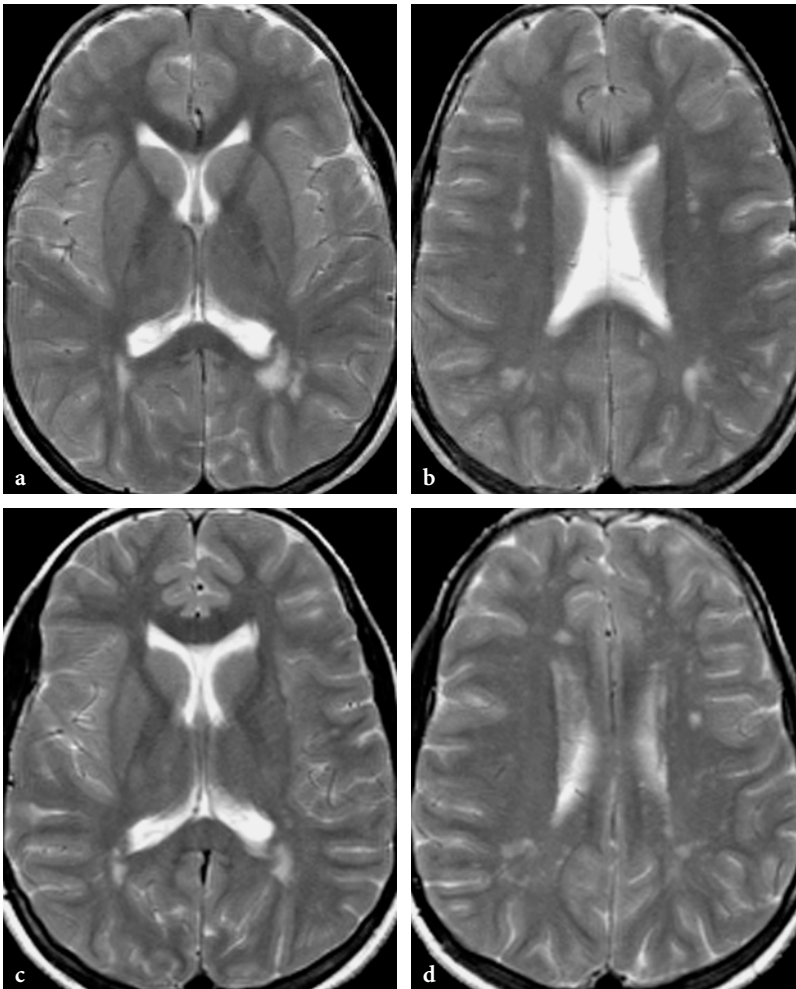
MR imaging findings in galactosemia in twin sisters (both images at the age of 13 years). Axial T2-weighted fast spin-echo images. a, b Patchy white matter lesions in the peritrigonal areas and within the centrum semiovale. c, d Identical findings as in her sister
